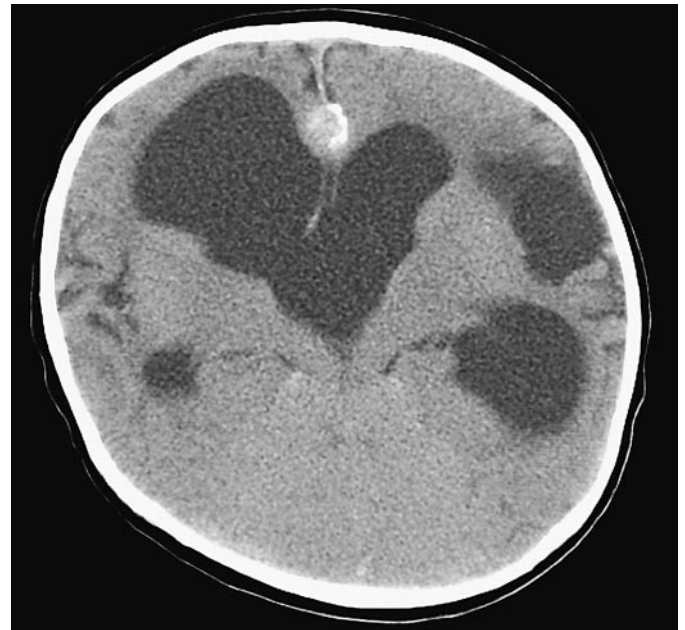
Noncontrast CT demonstrates obstructive hydrocephalus (with permission from Mayfield Clinic).
